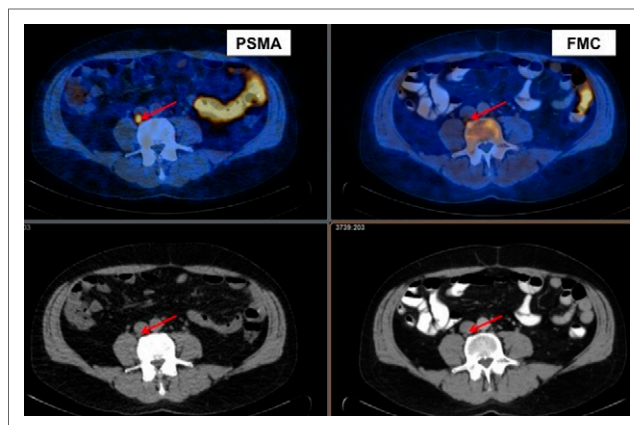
A 70-y-old man with Gleason 7 prostate cancer treated with radical prostatectomy who presented with rising PSA (12.0) and PSA doubling time of 5.8 mo. Both ^{18}F -fluoromethylcholine (FMC) PET/CT and ^{68}Ga -PSMA PET/CT were positive for nodal disease (4 lesions positive on ^{18}F -fluoromethylcholine imaging and 9 on ^{68}Ga -PSMA). However, TBR was higher for ^{68}Ga -PSMA than for ^{18}F -fluoromethylcholine (25.0 vs. 7.0 in this image of positive paracaval lymph node). Biopsy confirmed nodal recurrence of prostate cancer.
